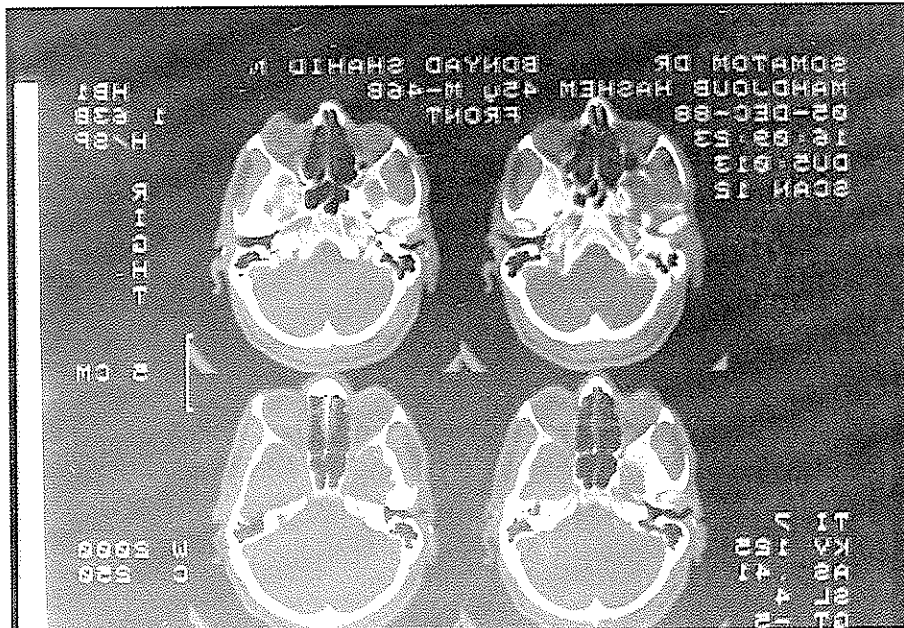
CT Scan of petrous bone with the contrast shows the widening of the right IAC.
